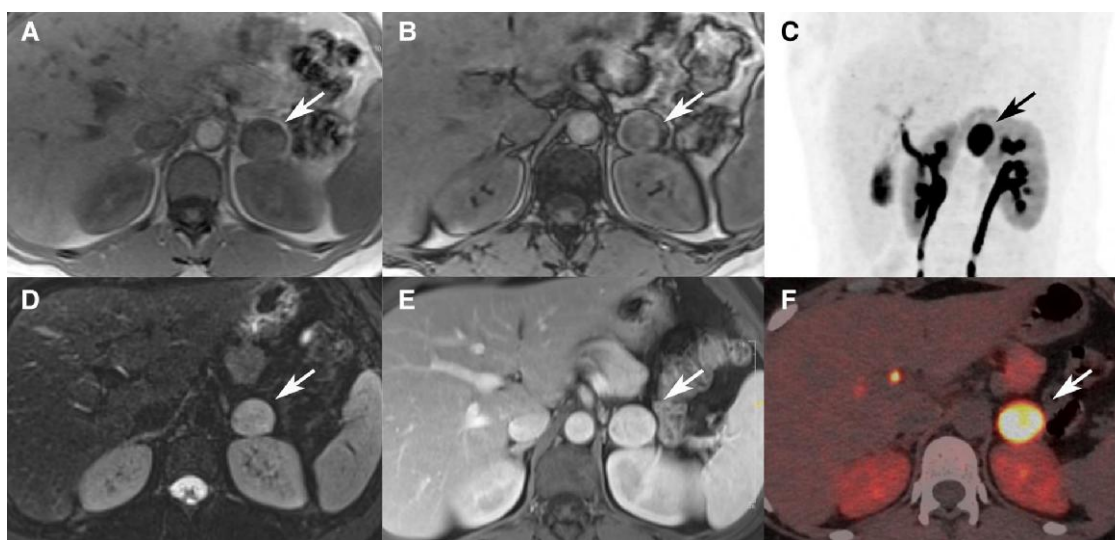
MRI and ^{18}F -DOPA PET/CT of PCC. MRI (A, B, D, E), ^{18}F -DOPA PET/CT (C, F). Homogeneous left adrenal mass hypointense on T1 MRI without loss of intensity between the in-phase (A) and out of phase images (B), intermediate high signal on T2 images (D), with hypervascular pattern at arterial phase (E). High tumor DOPA uptake on PET imaging (C: MIP image, F: axial PET/CT fused image).
